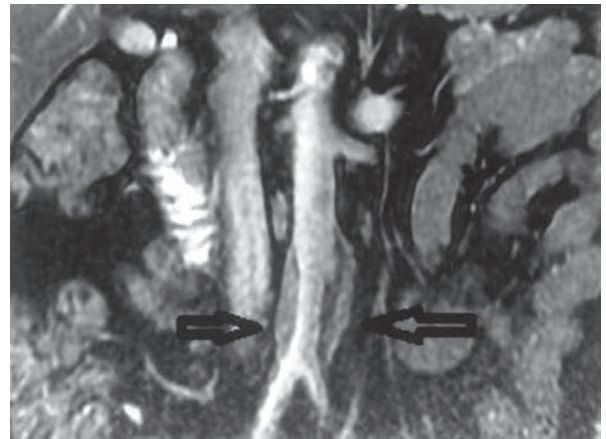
Coronal FIESTA MRI scan shows segmental infrarenal aortic wall thickening.
